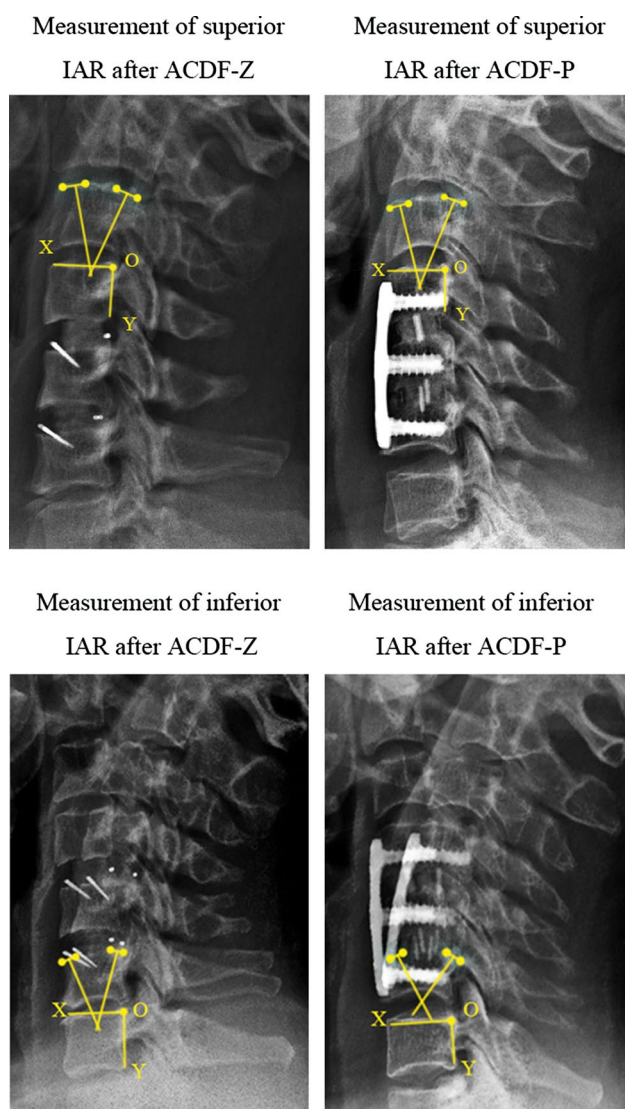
Measurement of the instantaneous axis of rotation (IAR) on flexion–extension plain lateral radiographs by superimposing the inferior cervical vertebrae in accordance with the method involving the perpendicular bisectors of AA' and BB' intervals and the establishment of coordinates
